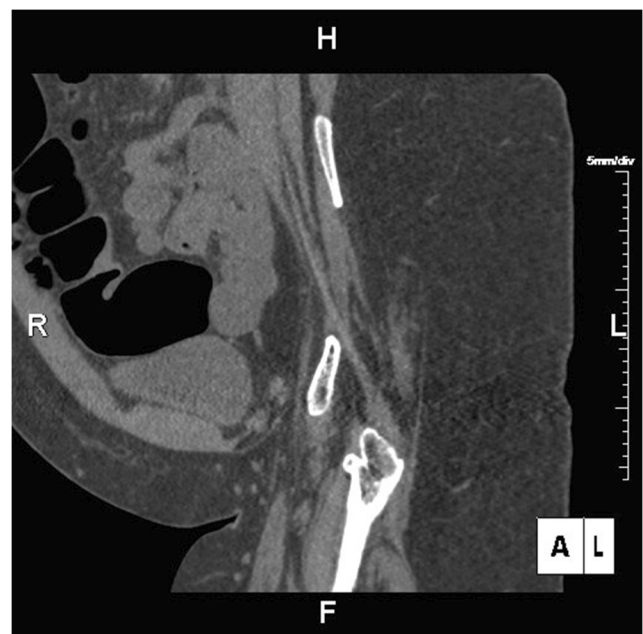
Sagittal oblique reformatted image from the non-contrast CT of the pelvis
